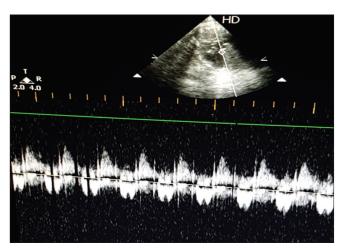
Fetal echocardiogram showing Doppler across mitral valve showing A wave dominance than E wave
